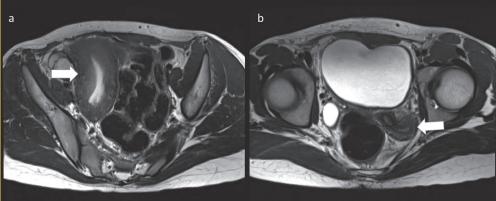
T2 MRI pelvis axial view. a) Uterus didelphys showing the larger right uterine horn with mild haematometra (arrow); b) the smaller left uterine horn (arrow)
